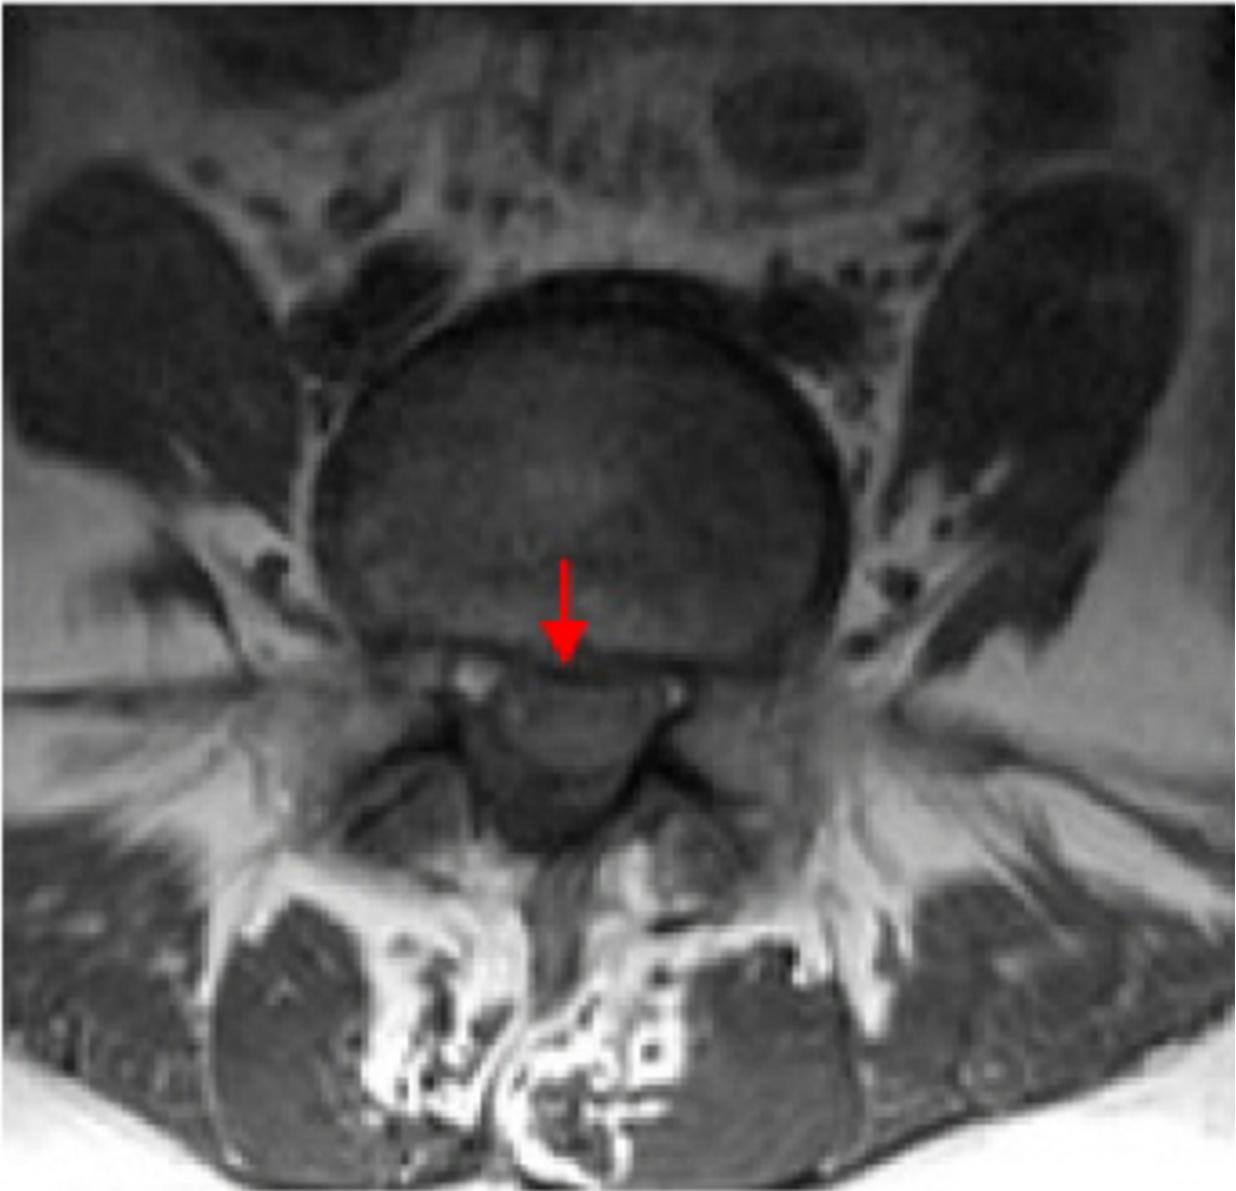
Axial T1 Weighted Lumbar Spine MRI image showing L4/L5 Large Disc Extrusion with severe canal compromise.
